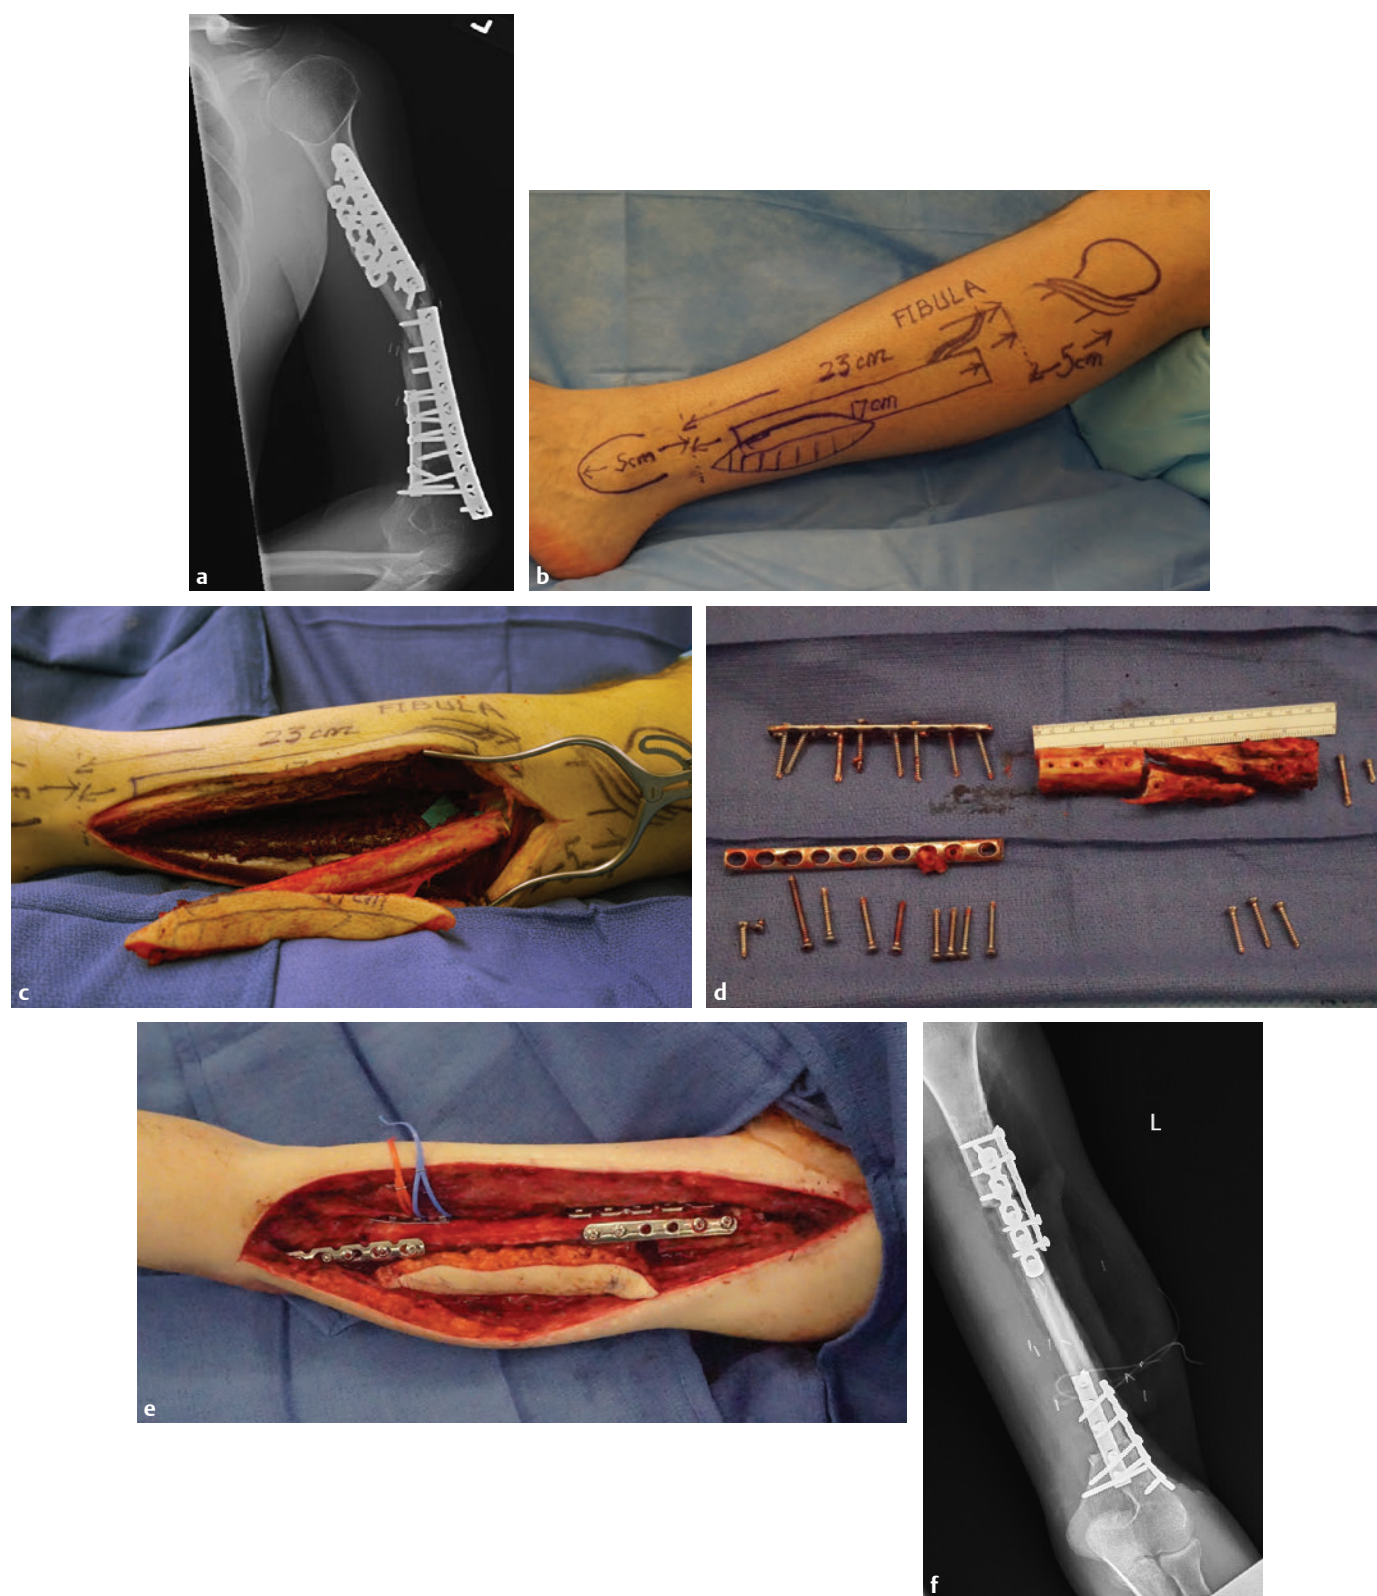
Fibular flap. (a) Radiograph revealing failed, comminuted allograft intercalary reconstruction after multiple revisions. (b) Design of fibular osteocutaneous flap. (c) Fibular flap raised and isolated on peroneal vessels. (d) Debrided hardware and allograft. (e) Inset, ORIF and revascularization of fibular flap. (f) Radiograph shows excellent incorporation after bone healing.
